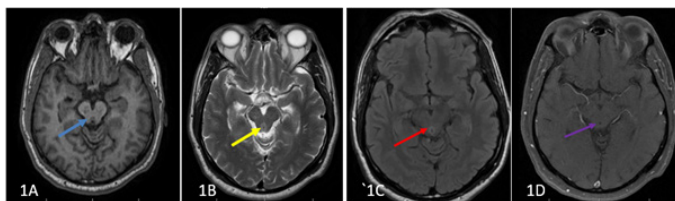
Axial MRI brain showing lesion in the midbrain tectum, towards peri-aqueductal grey (PAG) which is hypointense on T1 (1A), hyperintense on T2 (1B), hyperintense on FLAIR (1C), with minimal post contrast enhancement (1D)
